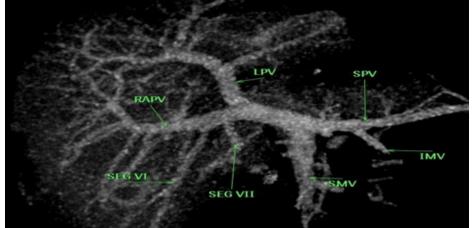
CT Portogram, MIP image showing Segment VI & Segment VII branchdirectly from Right Portal vein.
